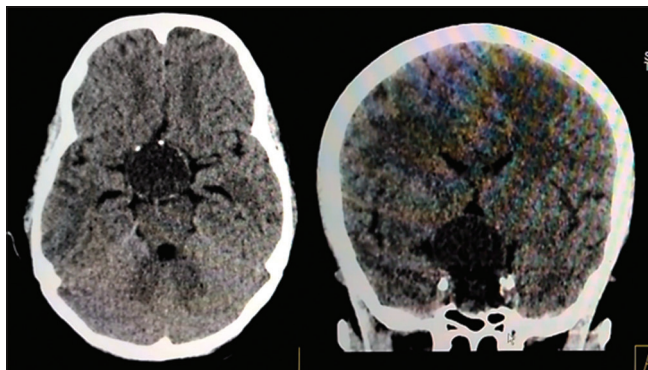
Computed tomography images of the lesion after meningitis showing the lesion to be of same size as before
